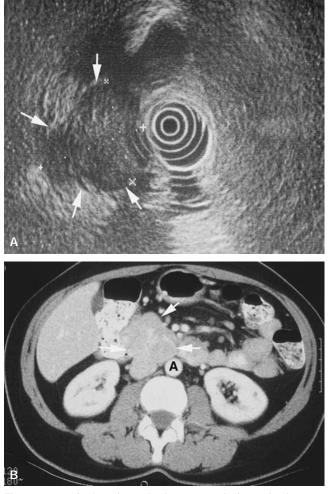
In *A*, endoscopic ultrasonography is used to image a large primary gastrinoma (*white arrows*). *B*, In this same patient, the location of the gastrinoma correlates with what is seen on computed tomography (*white arrows*). A = aorta.
